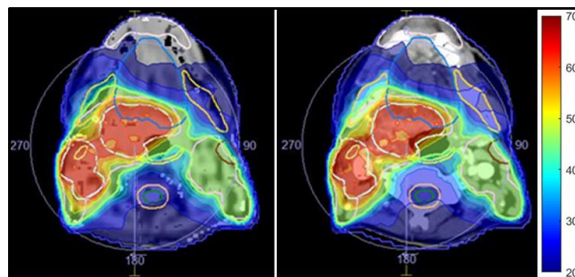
Dosimetry on the CT (top) and the sCT images (bottom) for a patient with laryngeal cancer; doses range from 20 (blue) to 70 (red) Gray.
